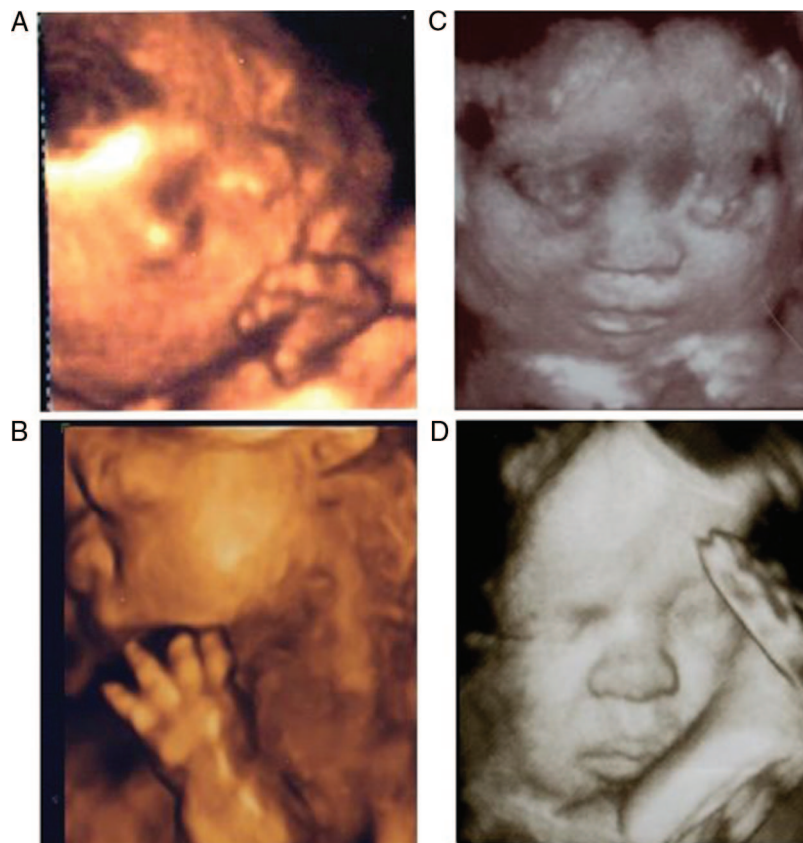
Three dimensional ultrasound images of fetuses demonstrating the abnormal facial images in thanatophoric dysplasia, achondrogenesis II and achondroplasia. A, Fetus with thanatophoric dysplasia showing severe nasal flattening and distorted facial shape because of craniosynostosis. B, Profile of fetus with thanatophoric dysplasia demonstrating severe nasal flattening and trident configuration of the hands (brachydactyly). C, Fetus with achondrogenesis II showing flattened nasal bridge but not as severe as thanatophoric dysplasia. D, Fetus with achondroplasia showing mild flattening of the nasal bridge.
